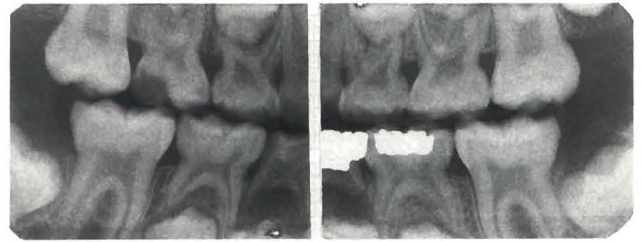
Magnified view of bite-wing radiographs.
